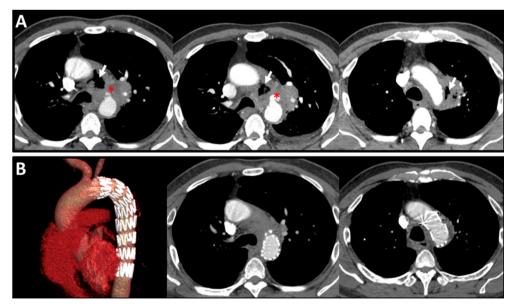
(A) Transverse view of contrast-enhanced CT of the aorta reveals 1.3×1.5 cm outpouching lesion protruded from the anterior aspect of proximal descending aorta (asterisks) with periaortic collection containing multiple air pockets (arrows). (B) Follow-up images after endovascular aortic graft implantation with carotid—left subclavian bypass graft show substantial decrease in size of periaortic abscess.
